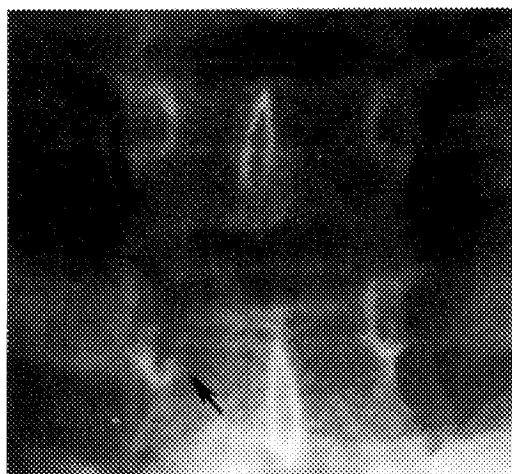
Plain film of the lower cervical and upper thoracic regions of the spine demonstrates a lytic lesion destroying the right pedicle of T3 (arrow).
